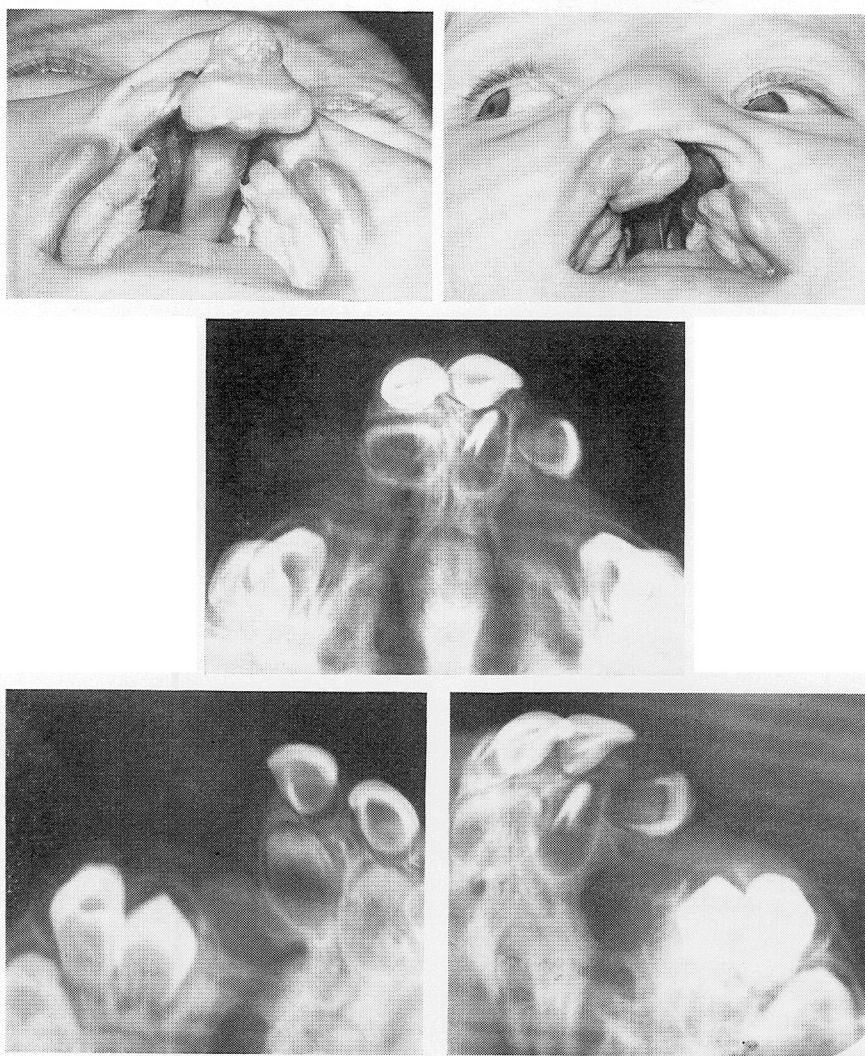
Condition in a boy at the age of three months when the primary cleft was repaired on the right side (upper left), and at the age of six months when closure of the left side was performed (upper right). Middle and lower, right and left, x-ray films at the age of 11 months show excellent relationship of maxillary segments. In special projections (lower), well-defined bone structures are clearly demonstrated bridging the maxillary cleft on both sides.
